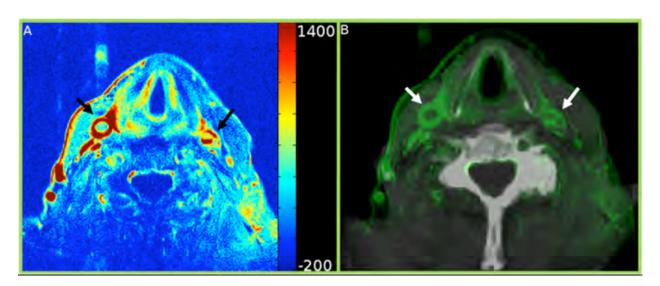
Area under the curve (AUC) map of a representative subject. Panel A, AUC map of the slice chosen for DCE-MRI acquisition. Black arrows indicate right common carotid and left common carotid. Panel B, Overlay of CT slice matching with slice chosen for DCE-MRI (gray color scale) and AUC map (green color scale). White arrows indicate right and left common carotid.
